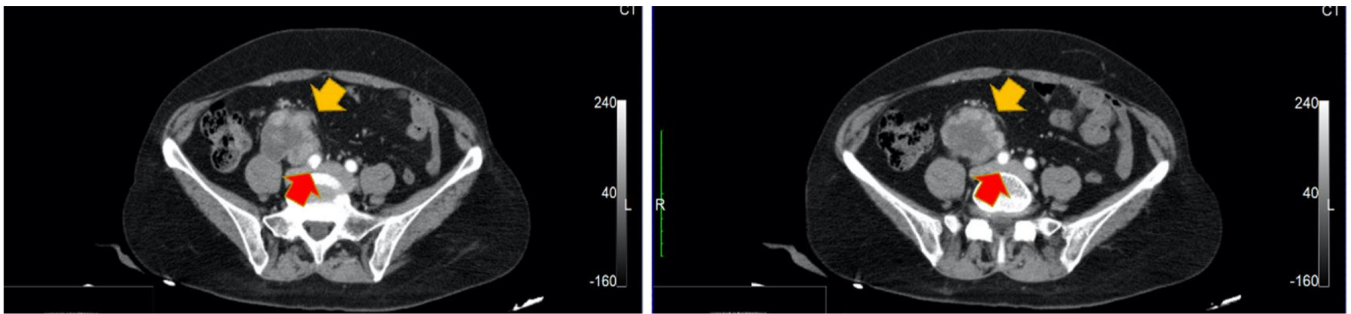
Computed tomography of the abdomen and pelvis. The yellow arrow indicates the leiomyosarcoma of the ureter, while the red arrow indicates the right common iliac artery.
